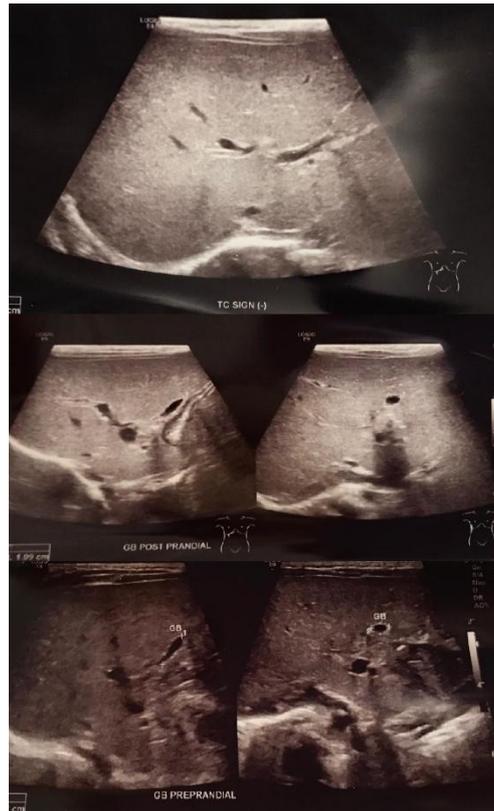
Abdominal ultrasound of the patient
